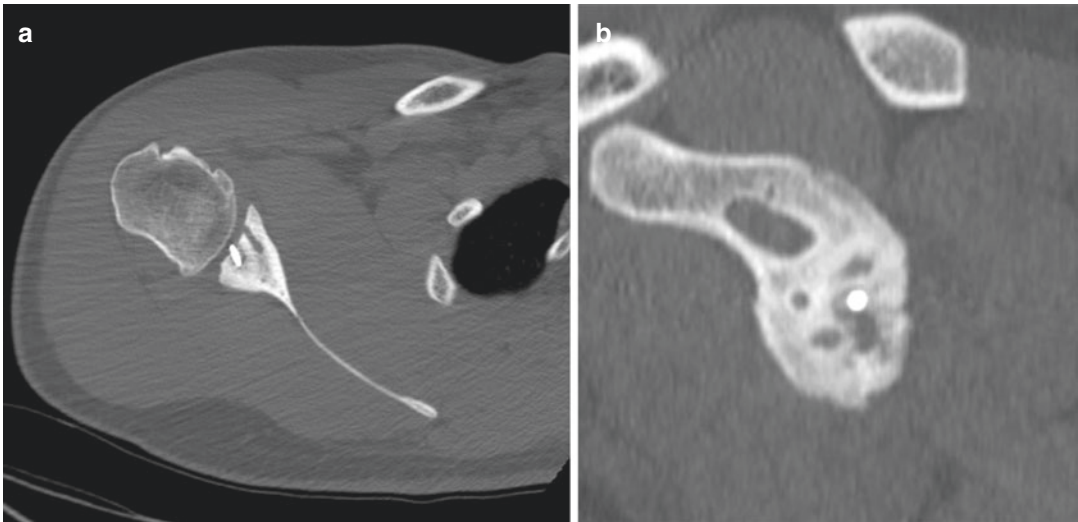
Computed tomography showing the wrong position of a metal anchor and the postoperative arthritis of the glenohumeral joint (a) transverse and (b) sagittal view
